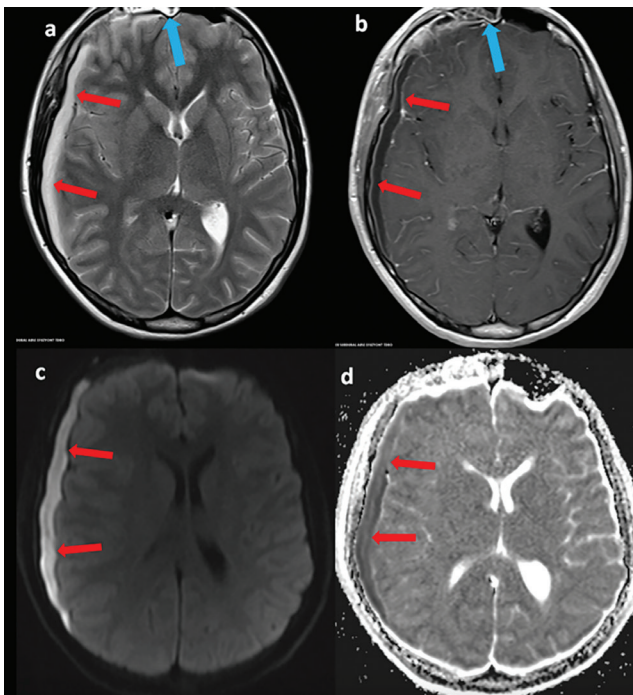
Nine-year-old male with frontal sinusitis complicated by subdural empyema. Contrast-enhanced brain MRI (a, b) and diffusion-weighted imaging (c, d) demonstrate right frontal sinusitis with mucosal thickening and enhancement (blue arrow). In the adjacent right frontotemporal region, a crescent-shaped extra-axial collection with peripheral enhancement and marked diffusion restriction is seen (red arrow), consistent with subdural empyema. Associated dural thickening and enhancement are evident, indicating inflammatory spread from the frontal sinus. Mild adjacent cortical edema and mass effect on the frontal lobe further support the diagnosis of intracranial extension secondary to sinusitis
